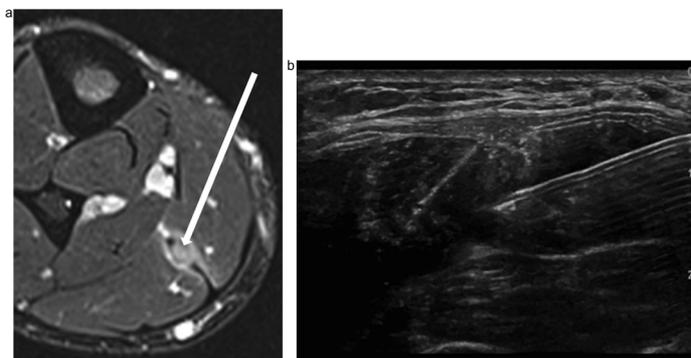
28-year old male soccer player with calf pain undergoing platelet rich plasma (PRP) intramuscular injection. (a) Axial STIR MRI image showing tear of the central intramuscular tendon of soleus (arrow). (b) Transverse sonogram showing 23 gauge needle with tip located in intra-muscular tendon of soleus at injury site.
